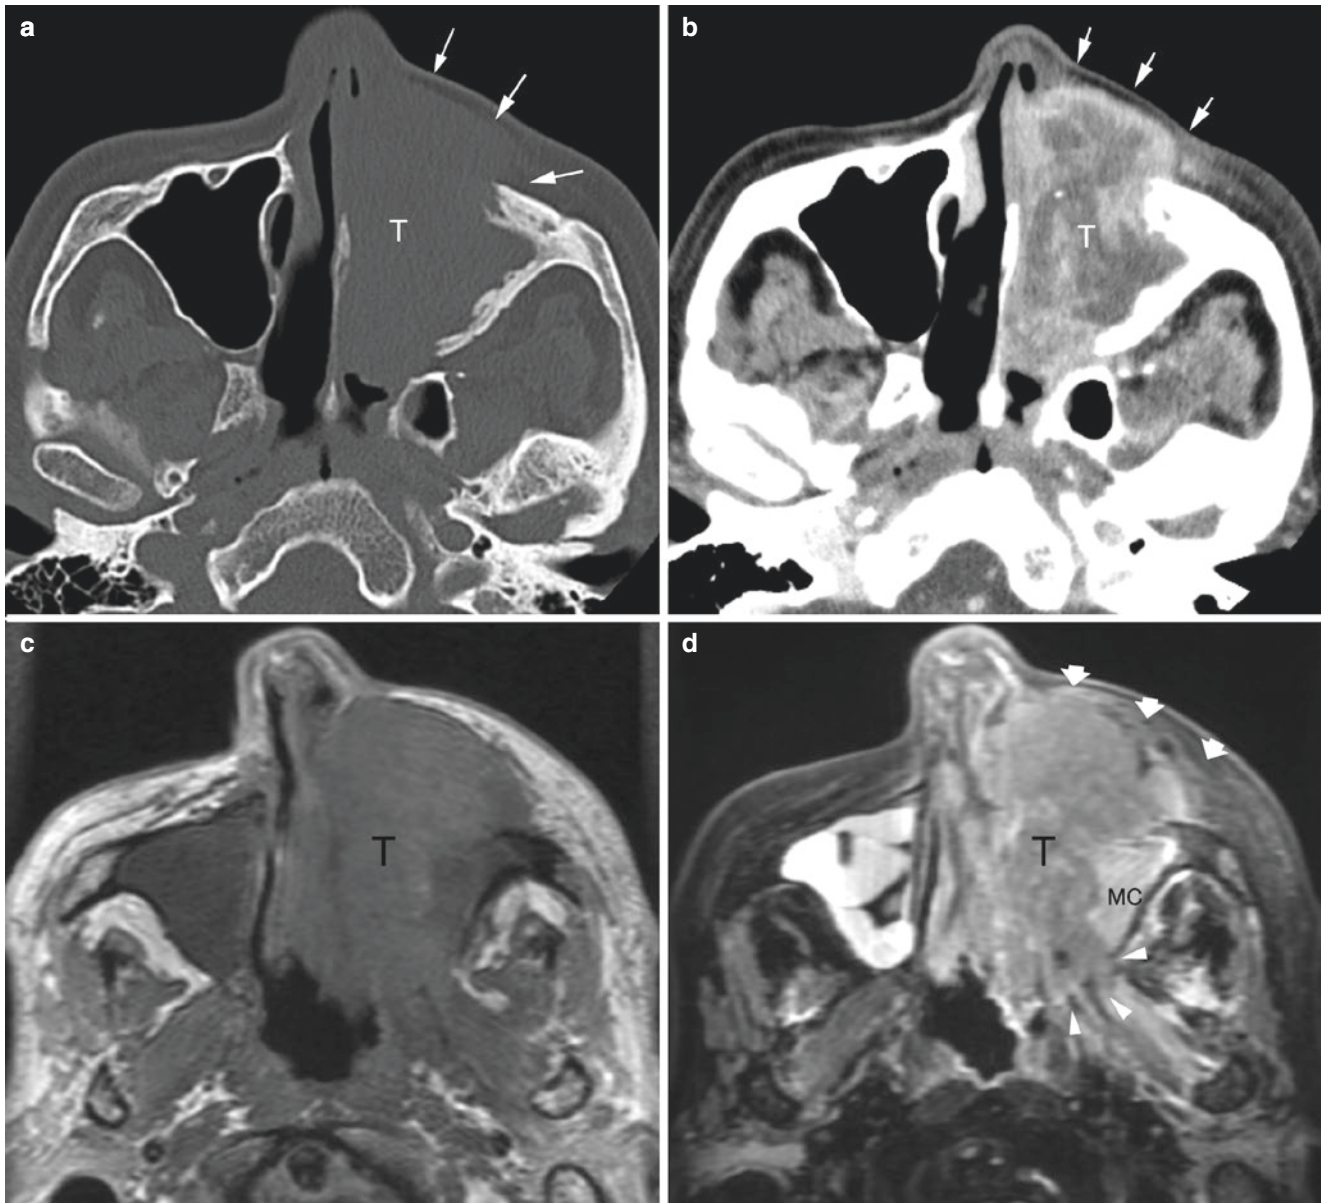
Squamous cell carcinoma of the maxillary sinus. (a) Bone algorithm CT. (b) Enhanced CT. (c) Axial T1-weighted image. (d) Axial T2-weighted image. (e) Axial Gd-enhanced T1-weighted image. (f) Axial Gd-enhanced T1-weighted image (cranial to b). (g) Coronal Gd-enhanced T1-weighted image. Contrast-enhanced (a) and bone algorithm (b) CT scans show an enhancing mass (T) in the left maxillary sinus massively destroying anterior bony wall (arrows). The medial wall is also destroyed. Axial T1-weighted (c), T2-weighted (d), and contrast-enhanced T1-weighted (e) images demonstrate a mass (T) in the left maxillary sinus. T2-weighted image allows separation of the neoplasm from trapped mucous collection (MC). Gd-enhanced
